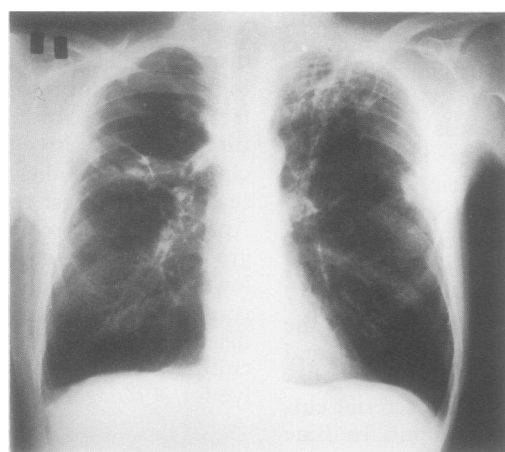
Chest radiograph of case 3 before death in June 1992.
